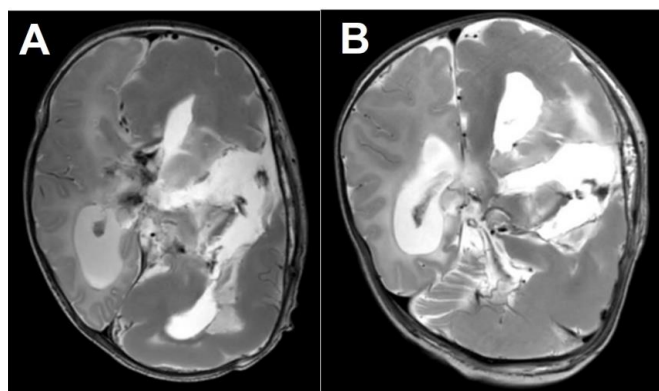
Postoperative magnetic resonance image performed after corpus callosotomy was performed (post-conceptual age 44 weeks and 0 days, 46 days of age, 6 days after operation). Posthemorrhagic hydrocephalus of the right ventricle was noted. (A) Axial view of T2-weighted image. (B) Coronal view of T2-weighted image.
